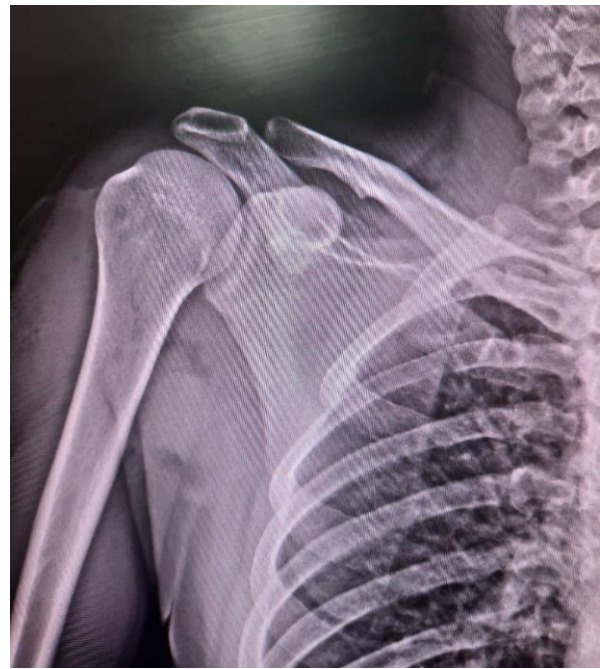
Postoperative radiograph of the right shoulder
